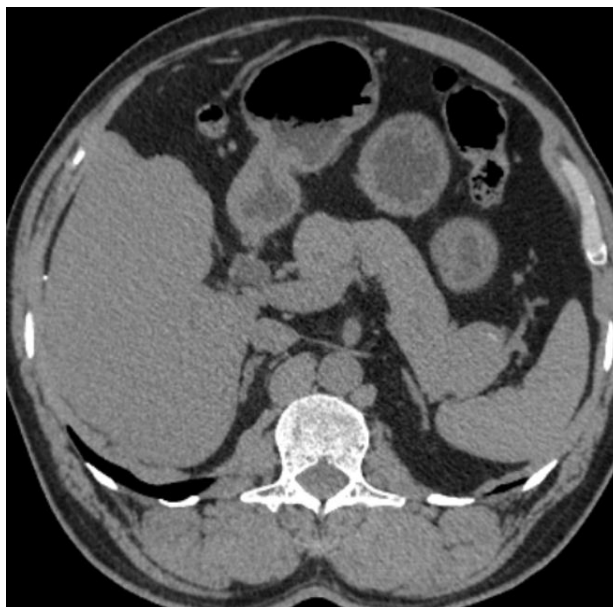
Axial section on CT showing straight, elongated B/L adrenal glands giving lying down adrenal sign.
